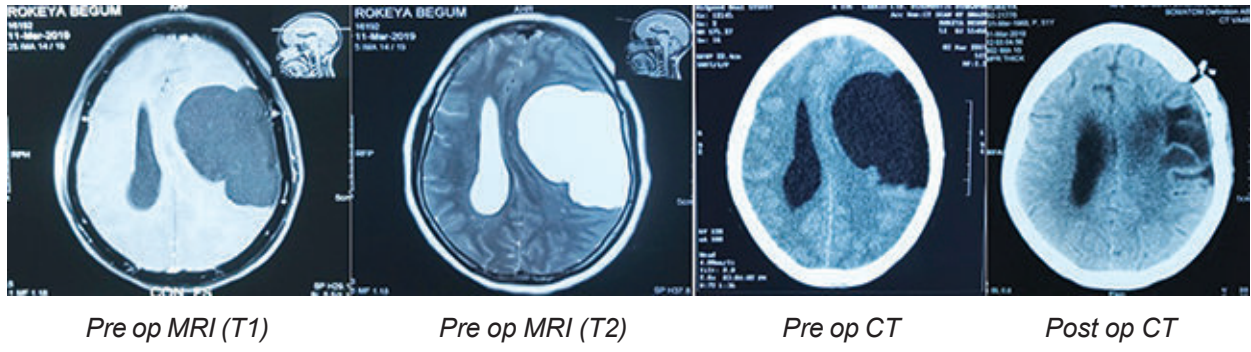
Pre operative MRI and CT scan of the brain with Post operative CT scan of the brain.
